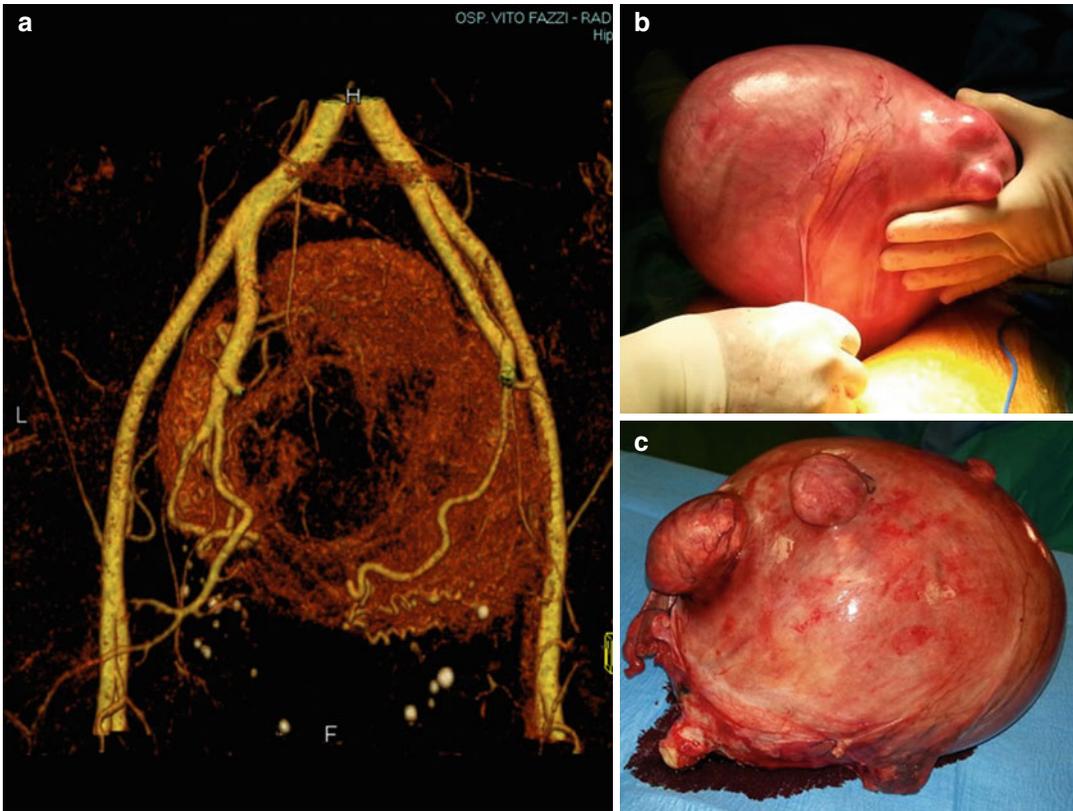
A giant fibroid of 24 cm of diameter: (a) an angio-CT reconstruction of the fibroid peripheral vascularization, as a surrounding vascular network;
